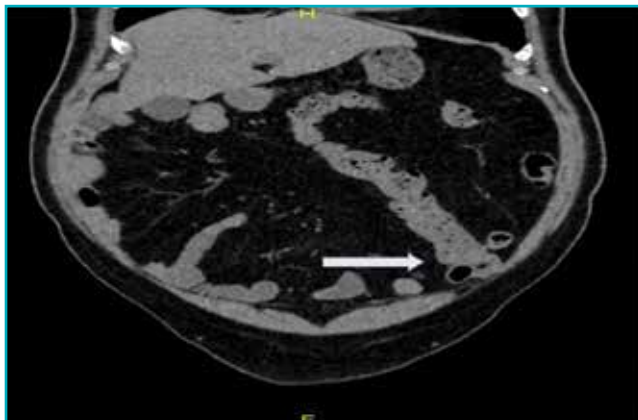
Plain coronal computed tomography (CT) image demonstrating a malpositioned cecum in the left iliac fossa with the ileocecal junction and ascending colon seen in the left half of the abdomen (white arrow).
